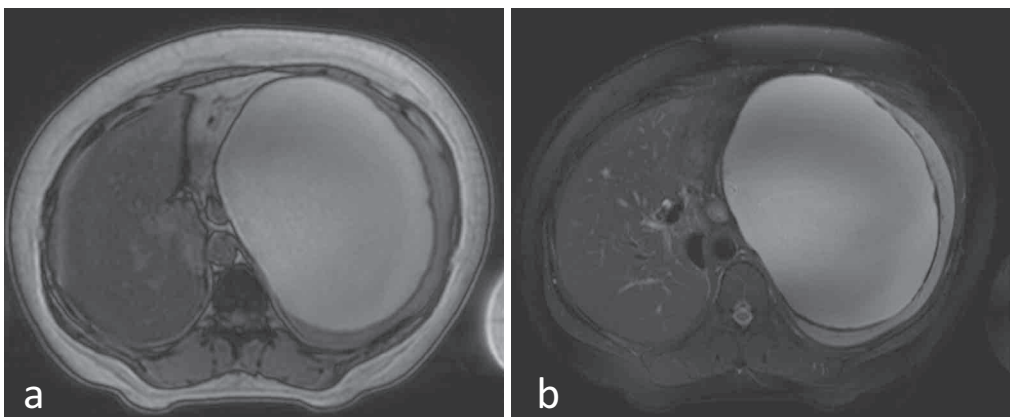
Abdominal MRI revealed high-intensity areas in the huge mass both with T1 (a) and T2 (b) weighted images.
